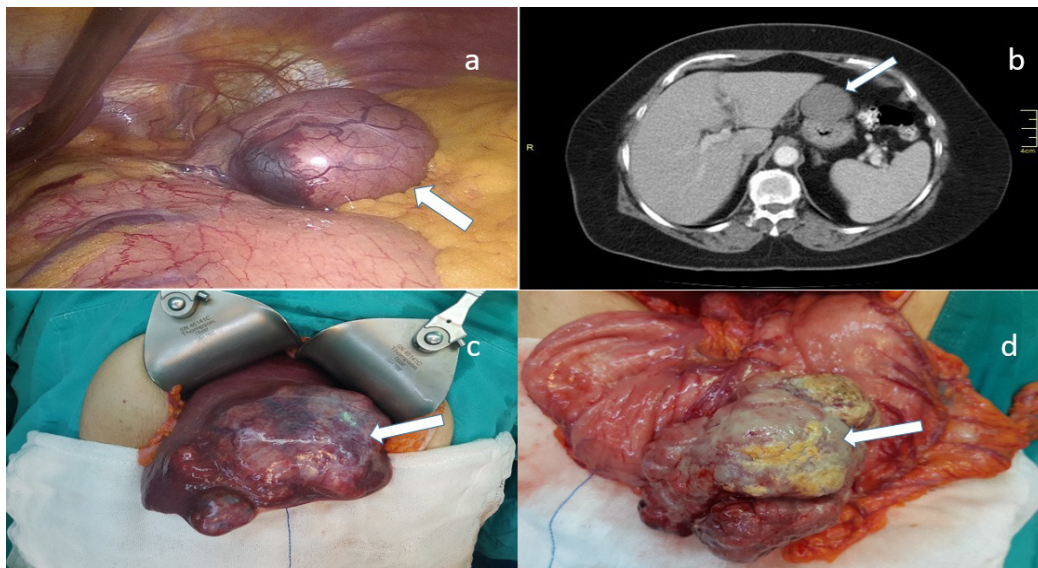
A) Intraoperative image of a gastric stromal tumor (GIST; white arrow) in a patient who underwent laparoscopic wedge resection; B) Computed tomography axial image showing GIST on the anterior wall of the stomach (white arrow); C) Intraoperative image of liver metastasis of the GIST (white arrow); D) Intraoperative image of GIST located in the anterior wall of the gastric antrum.
